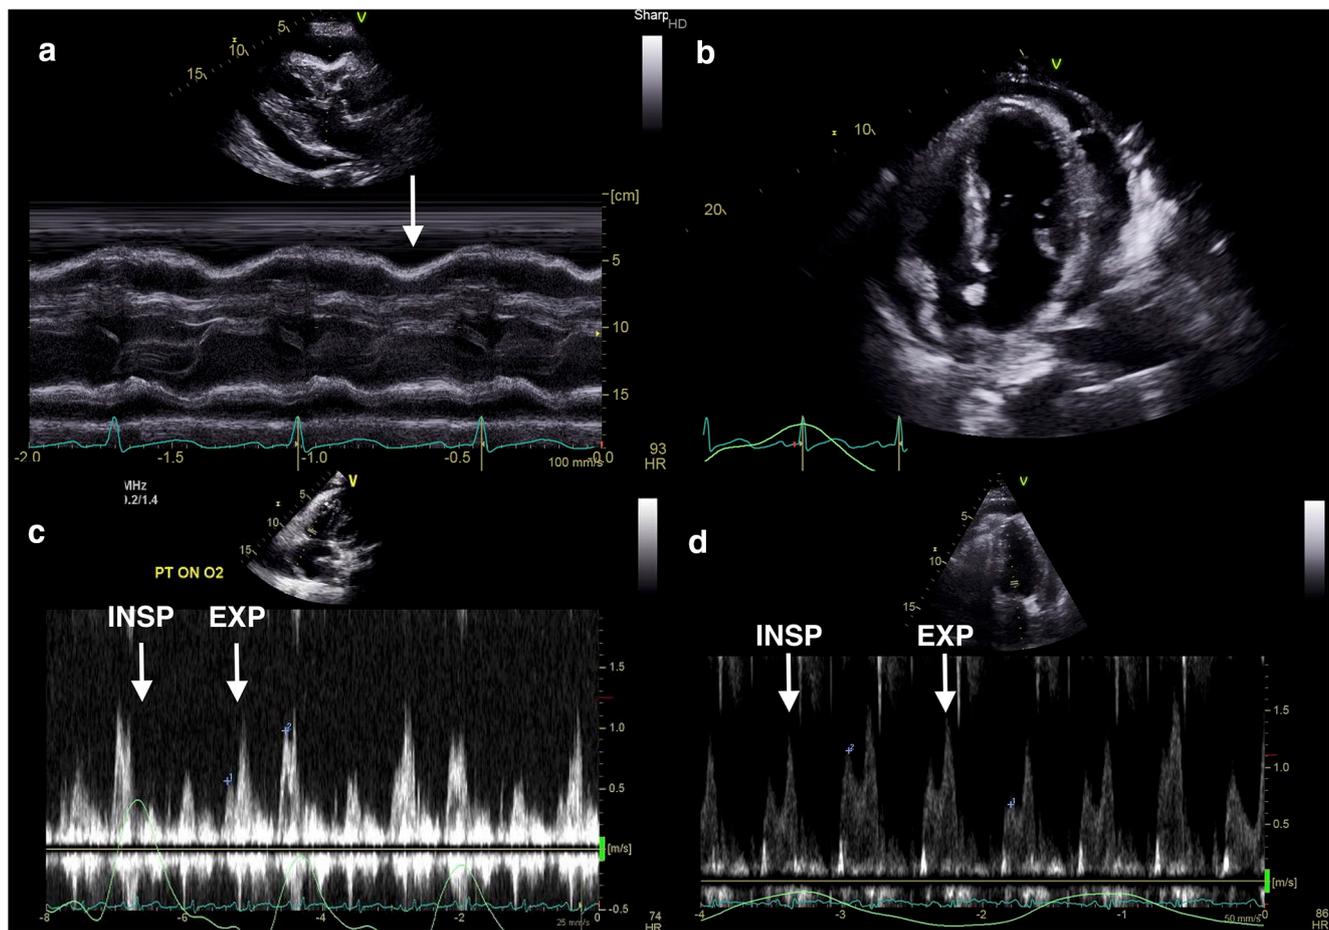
A 66-year-old woman with history of chemotherapy and radiation therapy for breast cancer 1 year prior presents with shortness of breath, and she is found to have a pericardial effusion with tamponade physiology. a Parasternal long-axis view with M-mode demonstrates right ventricular collapse during diastole (*arrow*). b Four-chamber
